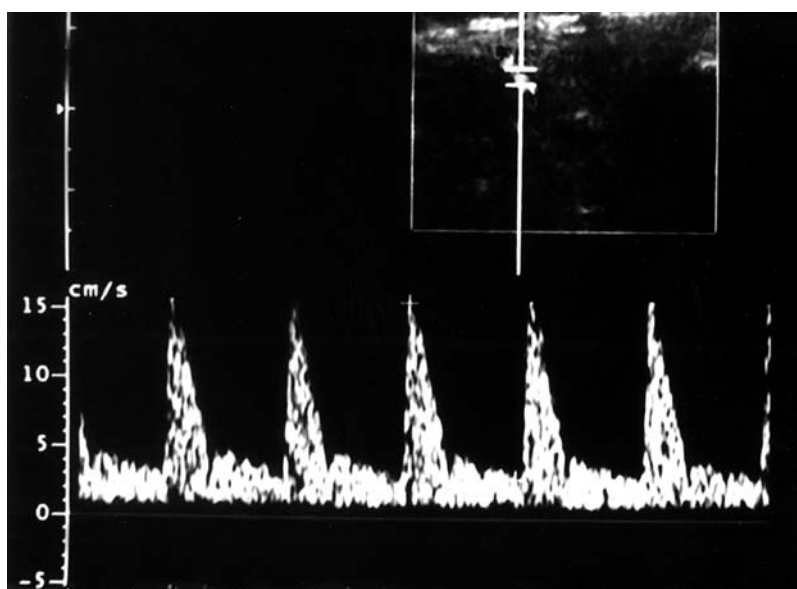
Doppler spectrum of the same joint in the same patient shown in Figure 3 after 12 weeks of anti-TNF therapy shows a high resistive index flow pattern reflecting regression of inflammation.
